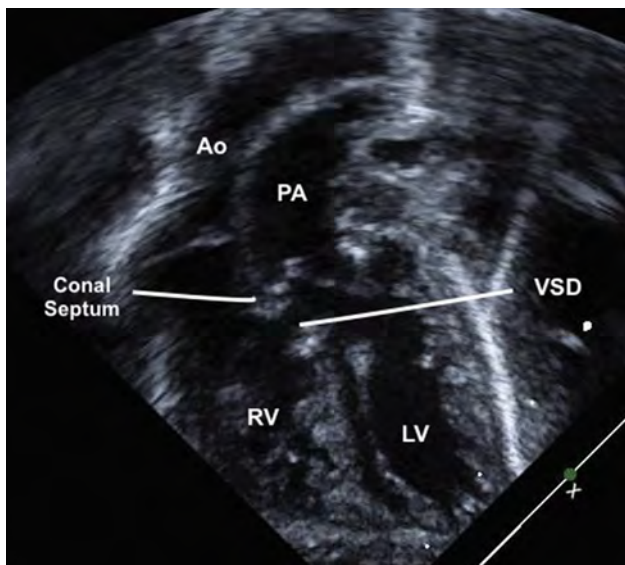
Apical five-chamber view of a patient with TGA and anterior malalignment type VSD demonstrates the conal septum deviated toward the right ventricle (RV) and the VSD sitting under the pulmonary valve. Not seen in this image is the fact that this patient also has transverse arch hypoplasia. Ao, Aorta; LV, left ventricle; PA, pulmonary artery.
